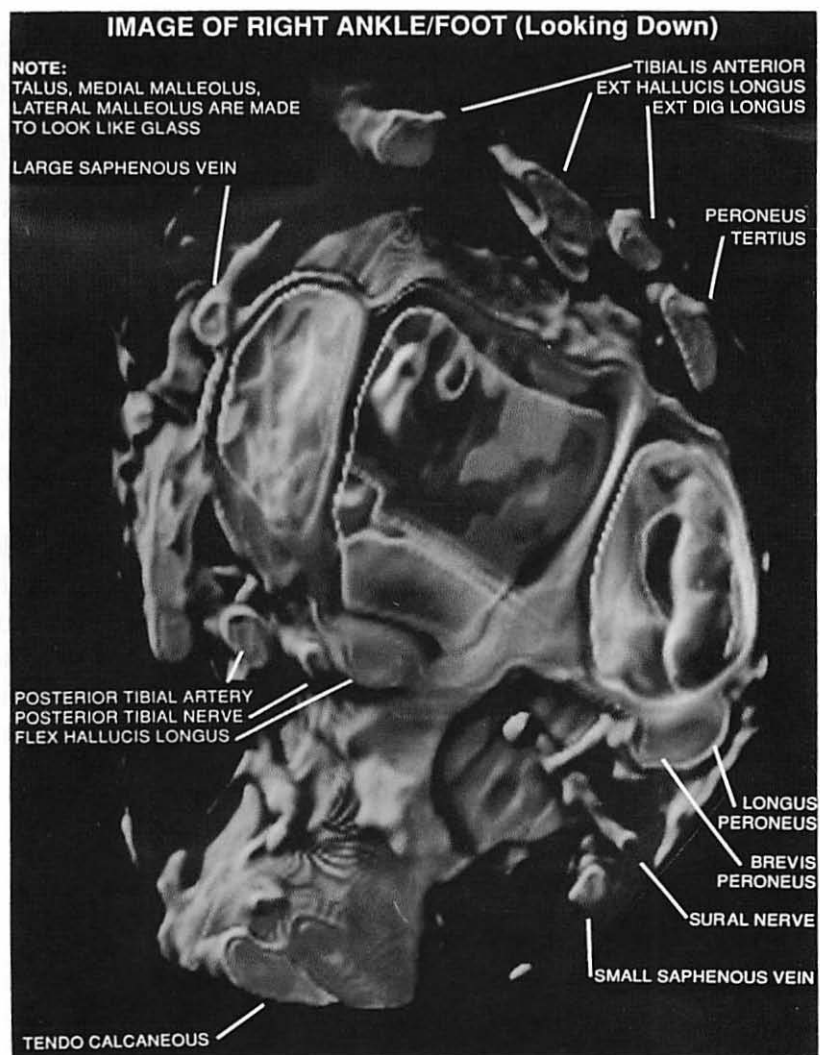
Rendering of Soft Tissue from CT Data
